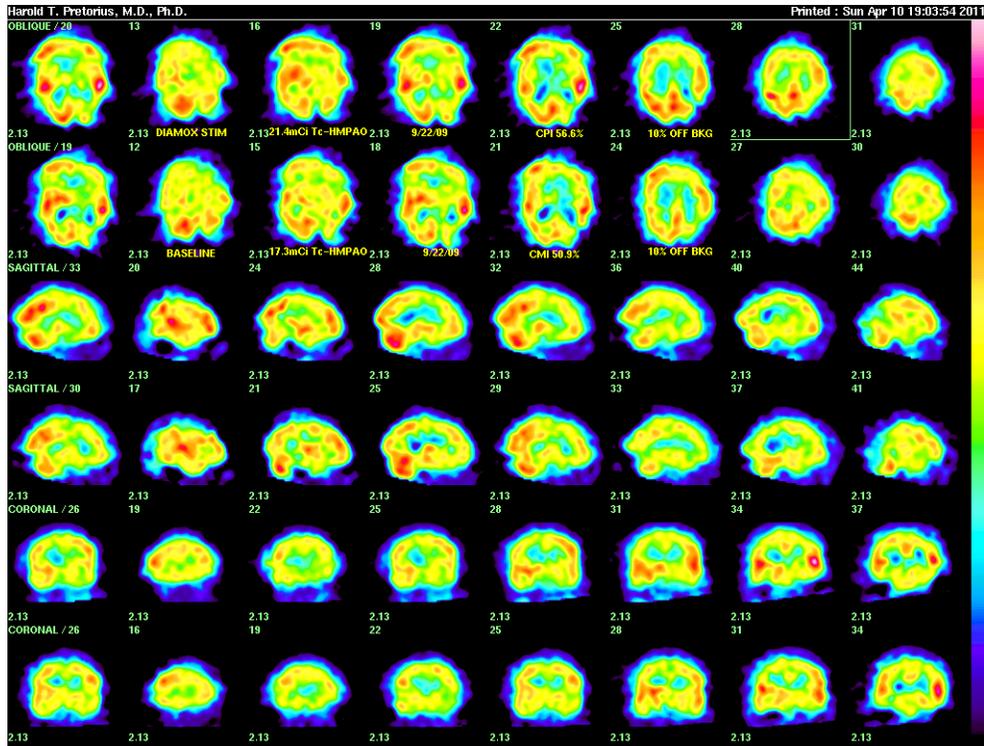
(above) Positive Effect of Incretin Therapy: A 56 year-old hypertensive, type 2 diabetic woman with memory loss (MMSE 26/30 and TYM 29/50) had abnormal CMi 50.1% and CPi 44.2% (abnormal CFi -5.9%) on baseline brain SPECT. Follow-up Brain SPECT after two years, shown below reveals CMi 50.9% and CPi 56.6% with normal CFi 5.7%, cf. low likelihood of disease patients CFi (6.67+2.83)% after control of hypertension with aliskirin (Tekturna), hyperlipidemia with atorvastatin (Lipitor) and glycemic control (for two years) with exenatide (Byetta). Stroke prophylaxis in this patient was cilostazol 100 mg oral twice daily. Her memory also subjectively improved and TYM increased from 29/50 to 34/50.
